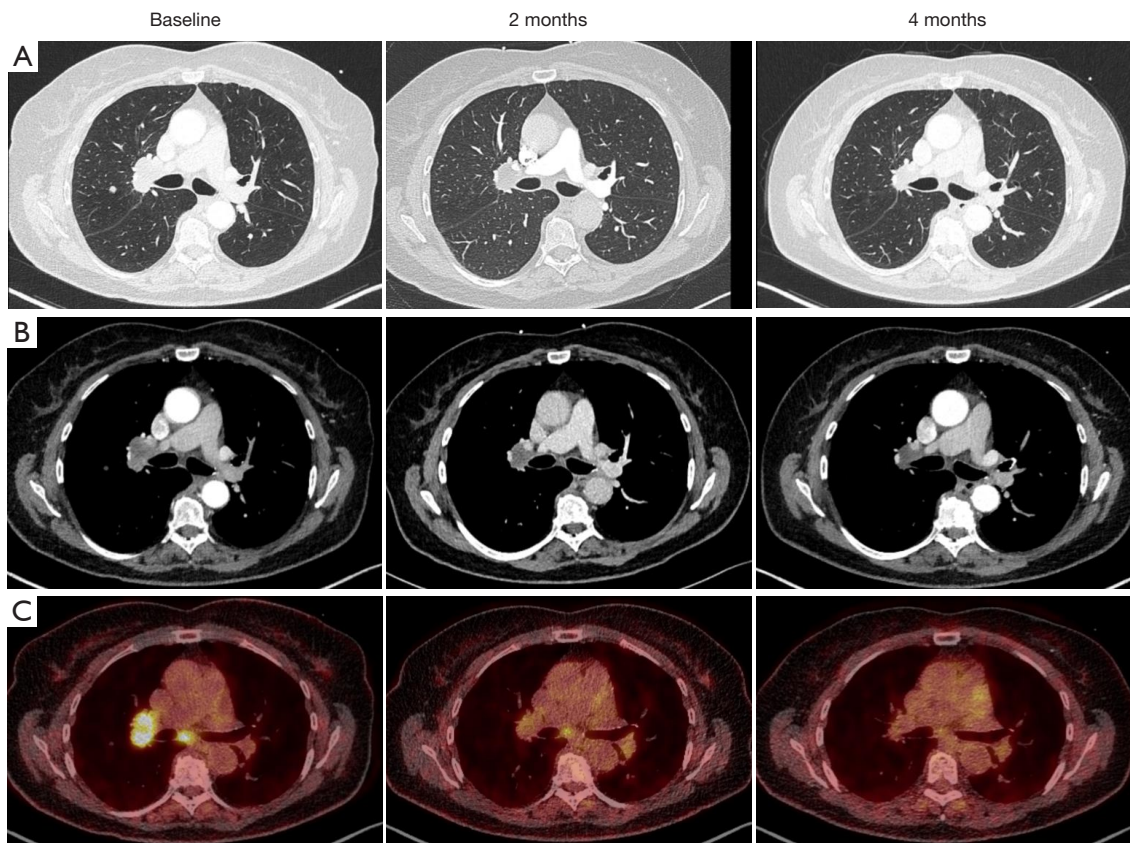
CT and PET/CT scan at baseline and after 2 and 4 months of neoadjuvant brigatinib. (A) Axial CT images, lung window. (B) Axial CT images, chest window. (C) Axial fused PET/CT images. CT, computed tomography; PET, positron emission tomography.
